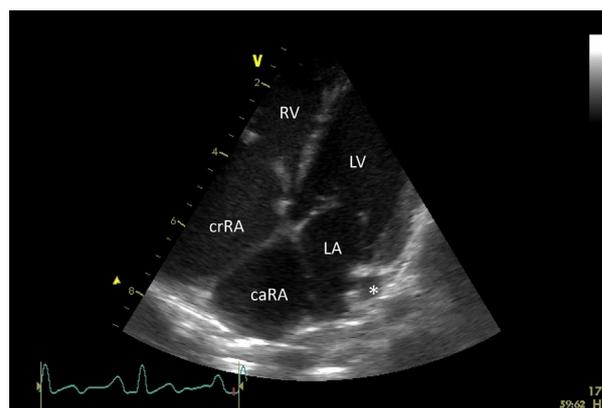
Two-dimensional echocardiographic image from the left apical imaging window demonstrating severe enlargement of the right atrium. A thin, perforate membrane is seen separating the right atrium into a cranial right atrium (crRA) and caudal right atrium (caRA), consistent with the cor triatriatum dexter. This image highlights associated congenital defects including thickened malformed mitral and tricuspid valve leaflets between the left atrium (LA) and the left ventricle (LV) and crRA and right ventricle (RV), respectively. *Dilated coronary sinus.
